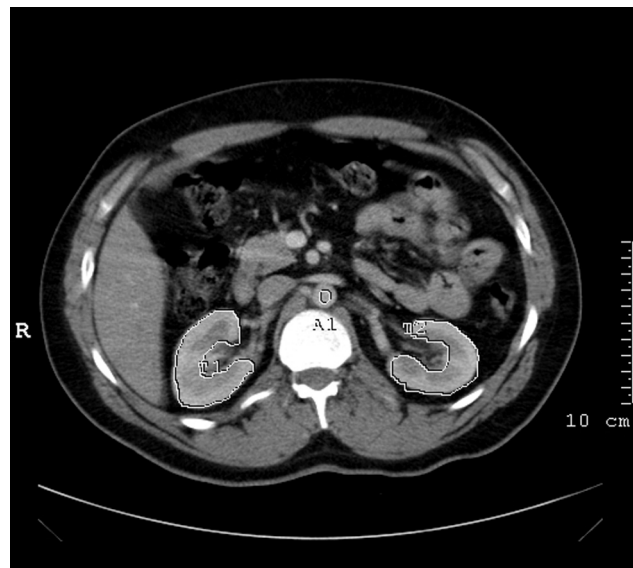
Axial perfusion CT image shows ROIs around the renal cortex and medulla.
